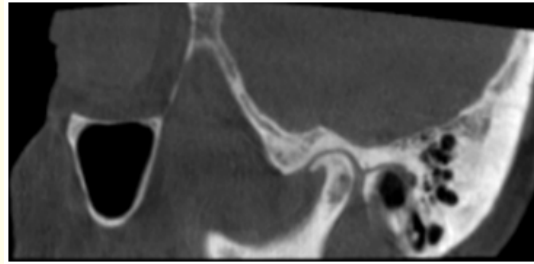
In the oblique sagittal section view of the CBCT, osteoarthritis is shown as a deformed joint with a condylar osteophyte and subcortical sclerosis in the condyle and fossa on CBCT [9].
